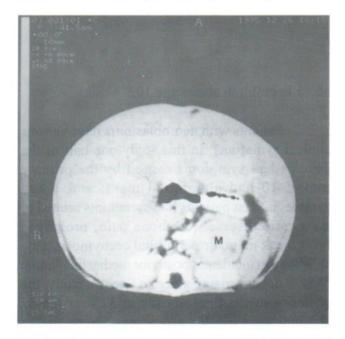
Contrast CT scan shows a well-defined left suprarenal mass (M) and diffuse inhomogeneous density of the liver caused by metastases.
